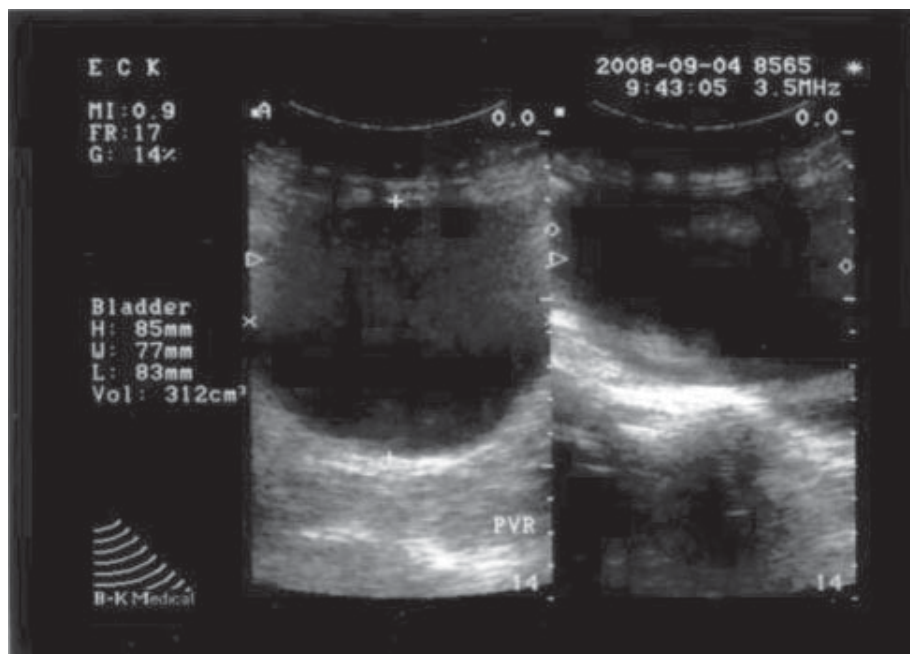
Supra-pubic sonography showed a huge anechoic tumor which was suspected to be a distended bladder.
